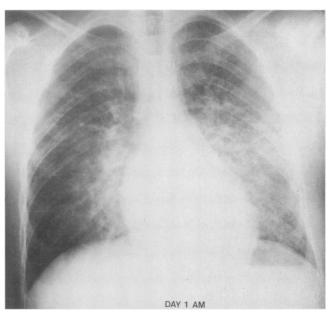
Erect posteroanterior chest radiograph of patient in case 7 on the third day of illness, ten hours after hospital admission. Symmetric reticular and alveolar densities radiate from the hila bilaterally. The heart is at the upper limits of normal in size. Kerley B lines are very prominent in the lateral costophrenic angles. The radiographic findings are compatible with cardiac decompensation, pulmonary edema and symmetric pulmonic infiltrates of pneumonia.
